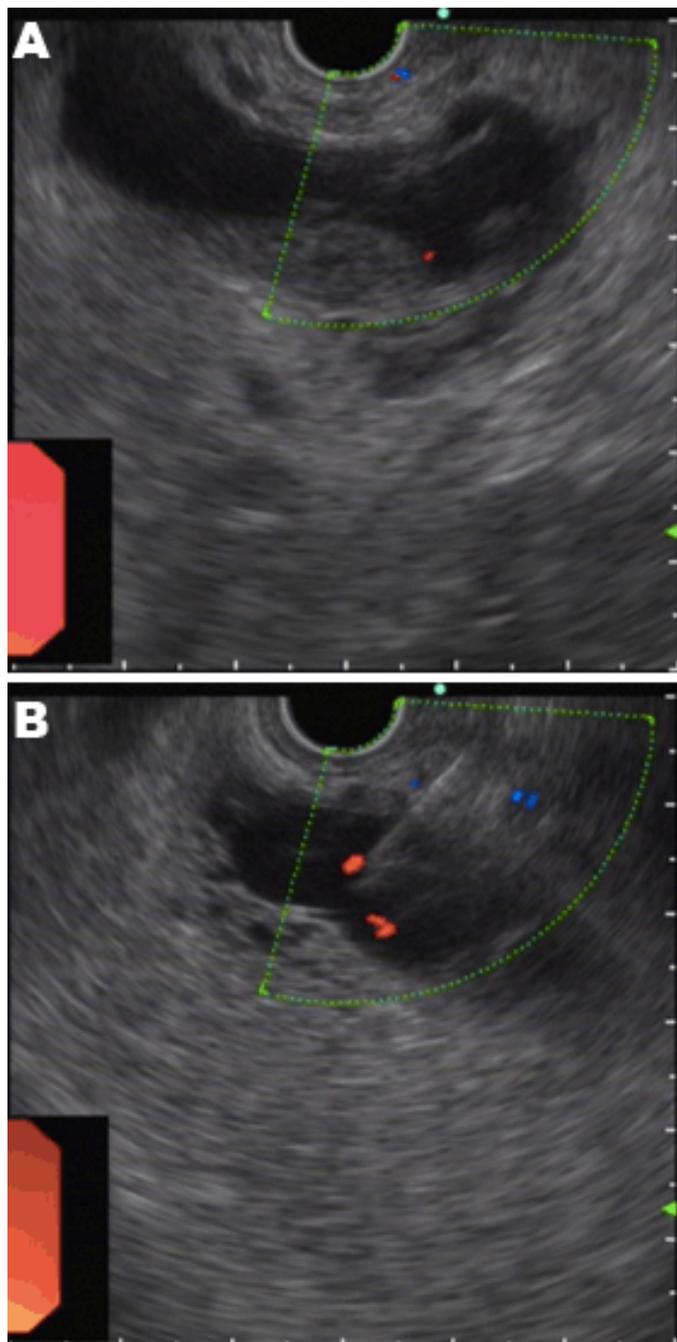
(A) EUS view of the pancreatic cystic lesion. Radial scanning EUS image (5 mHz) showing cyst in pancreatic head. Color Doppler ultrasound was used to exclude interposed vessel in the needle path, (B) FNA was performed under EUS guidance after advancing needle through the mucosa of duodenal wall and into the targeted lesion in pancreatic head.
